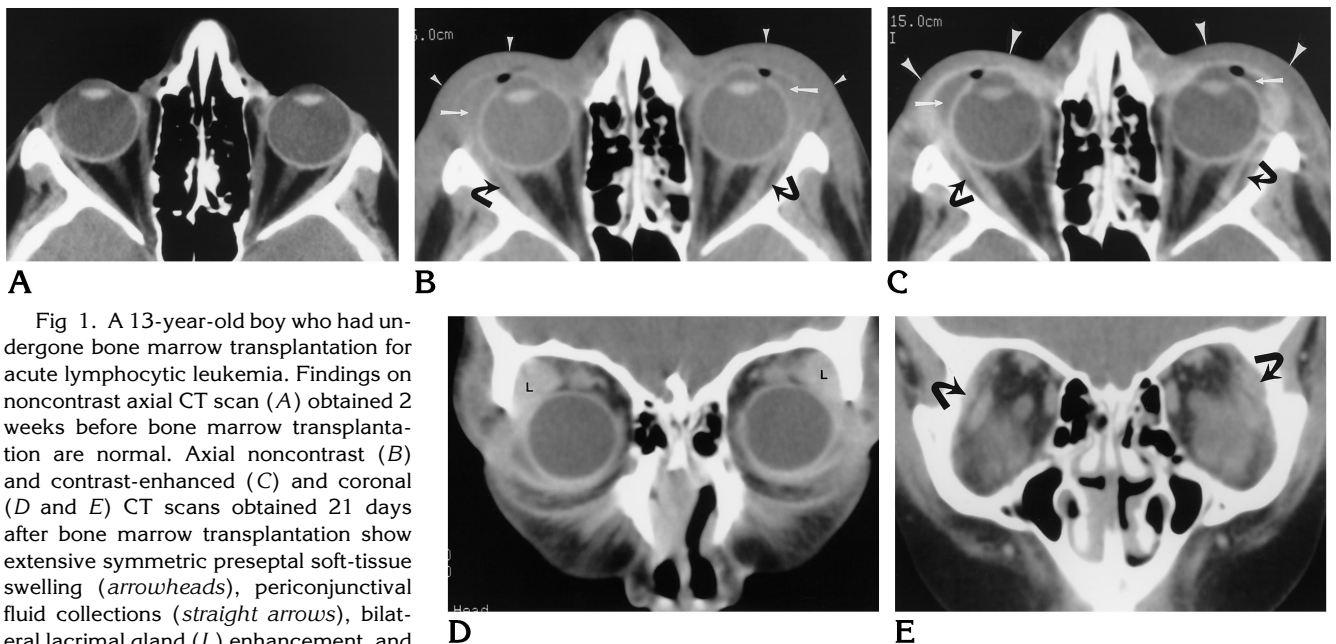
A 13-year-old boy who had undergone bone marrow transplantation for acute lymphocytic leukemia. Findings on noncontrast axial CT scan (A) obtained 2 weeks before bone marrow transplantation are normal. Axial noncontrast (B) and contrast-enhanced (C) and coronal (D and E) CT scans obtained 21 days after bone marrow transplantation show extensive symmetric preseptal soft-tissue swelling (*arrowheads*), periconjunctival fluid collections (*straight arrows*), bilateral lacrimal gland (L) enhancement, and minimal postseptal lateral extraconal inflammatory changes (*curved arrows*).
